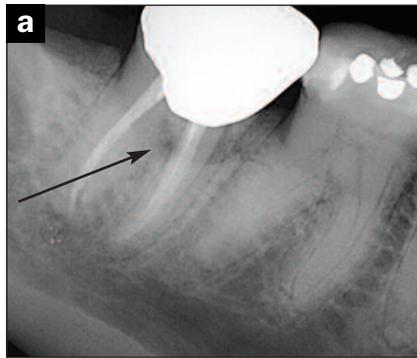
The digital periapical radiograph revealed likely periodontal involvement.
